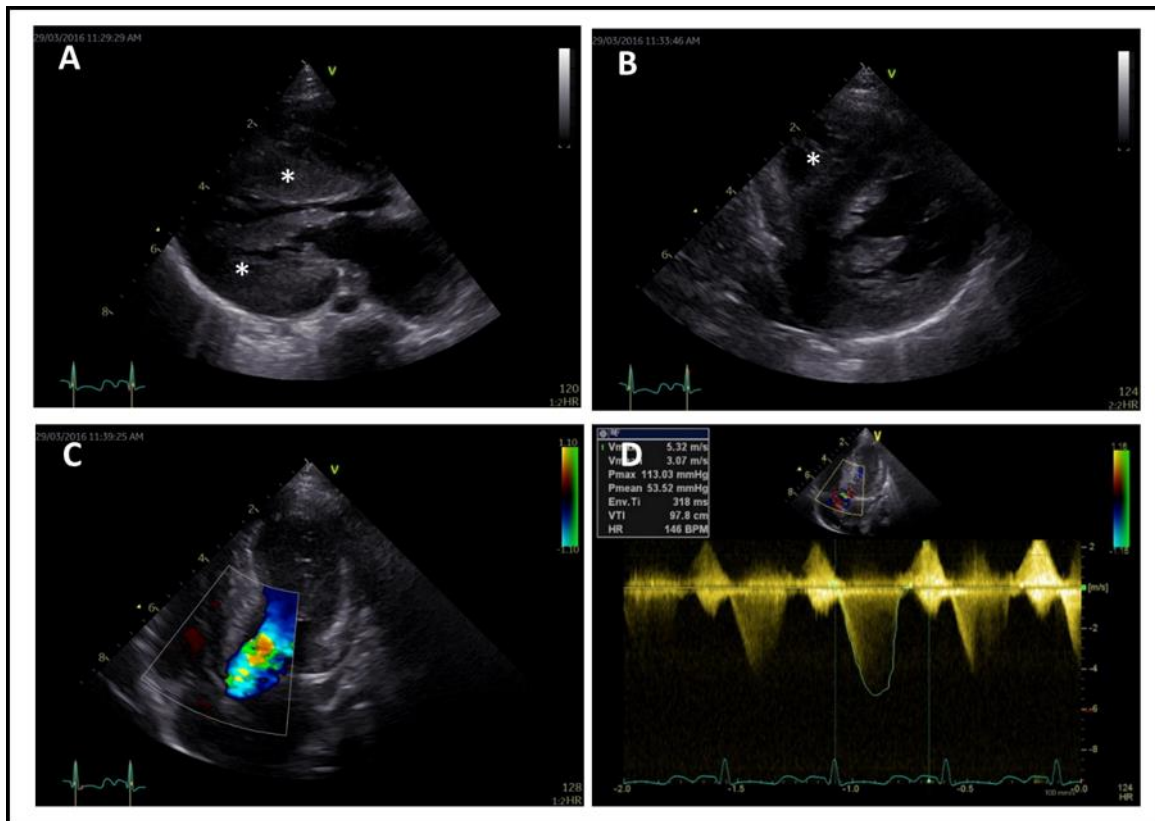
Echocardiographic images of patient 8, Related to Figure 1. Transthoracic echocardiographic imaging of patient 8 (Noonan syndrome, *RAF1*, female, 12 months of age) at the time of admission to the hospital for surgical left ventricular outflow tract resection. Depicted are the parasternal long axis view (panel A), parasternal short axis view (panel B), and the apical 5-chamber view (panel C and D) with color Doppler (panel C) and continuous wave (CW) Doppler (panel D) imaging. There is severe myocardial thickening (*), the peak gradient over the left ventricular outflow tract measures 140 mmHg.
